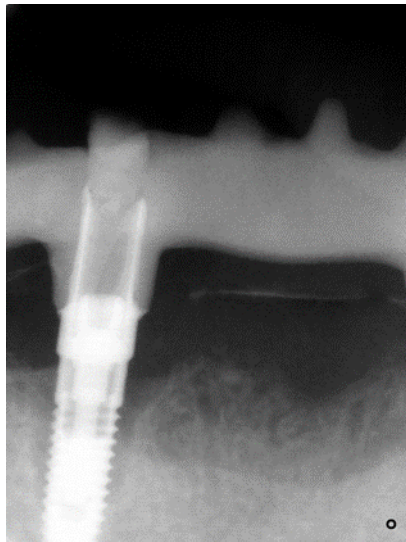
Intraoral radiographic image shows advanced peri-implant marginal bone loss.
